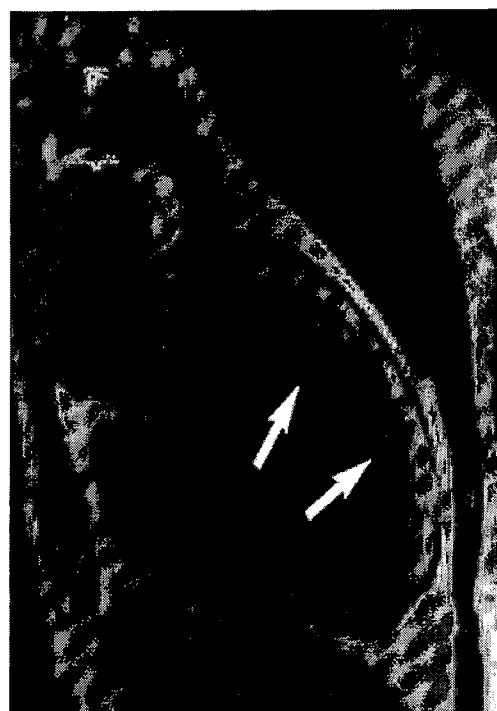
Contrast enhanced magnetic resonance imaging: vertical long axis view (equivalent to two-chamber echo view) demonstrating hyperenhancement of the inner 50–75% of the entire anterior wall (arrow). The scar is located on the endocardial surface (white), with live epicardium (black) seen as a thin rim outside the scar. Non-infarcted segments are black throughout the wall: outside the epicardium is a ring of white (pericardial fat).
